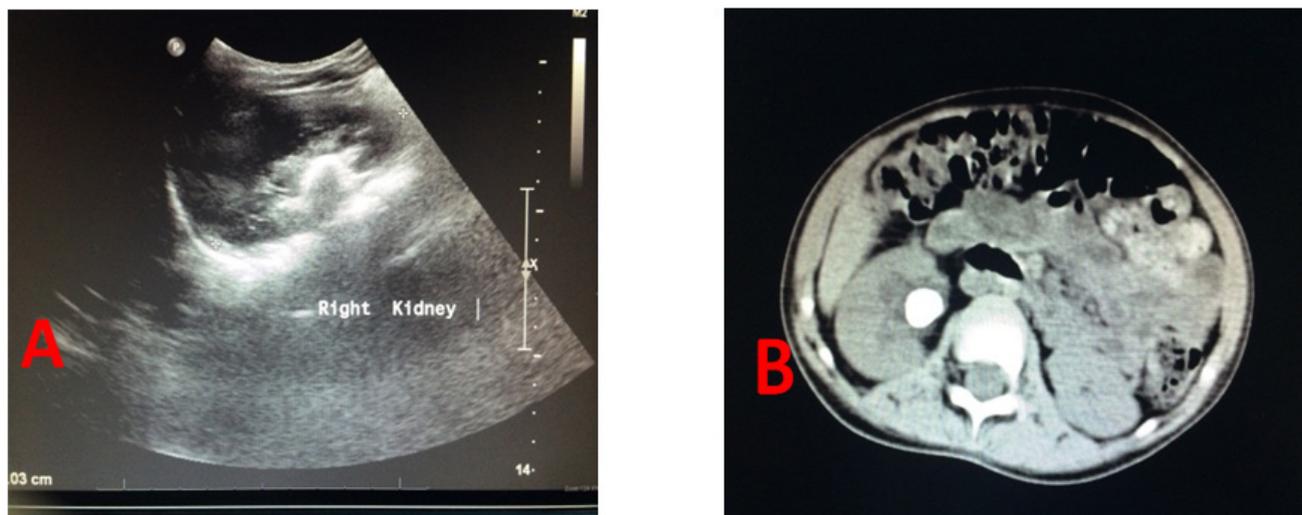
(A) Right kidney US; (B) CT scan of abdomen (cross section), both showed right kidney stone measuring 16 mm at the renal pelvis
